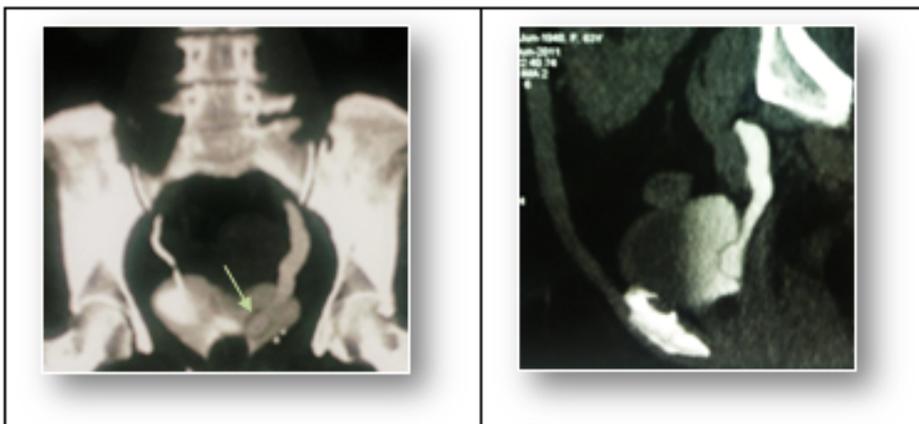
Coronal and sagittal MIP images from a CT Urography study showing an orthotopic ureterocele (arrow) on left side giving a “Cobra head appearance” due to surrounding opacified urine in the urinary bladder.
